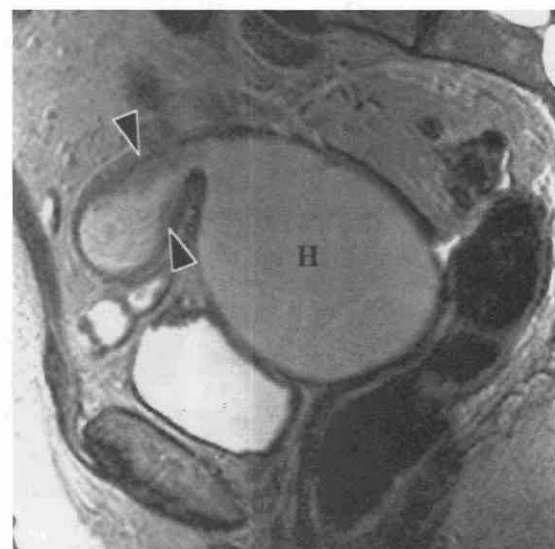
Endometrial carcinoma with hematometra. Sagittal T2-weighted image (TR = 5833 msec, TE_{eff} = 126 msec) shows the uterine and endocervical canals to be markedly distended with hemorrhagic fluid (H). The irregular tumor (arrowheads) lines the endometrial cavity. TE_{eff}, effective echo time.
